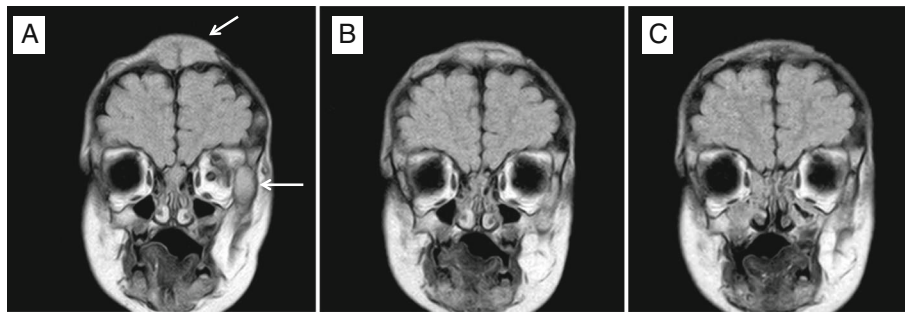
MRI Frontal view (seq. eFLAIR_long_TR_CLEAR). Two lesions of the left orbit and the skull in the fronto-parietal region (bars). a Before sunitinib treatment. b Day + 56 of sunitinib. c Day + 156 of sunitinib
